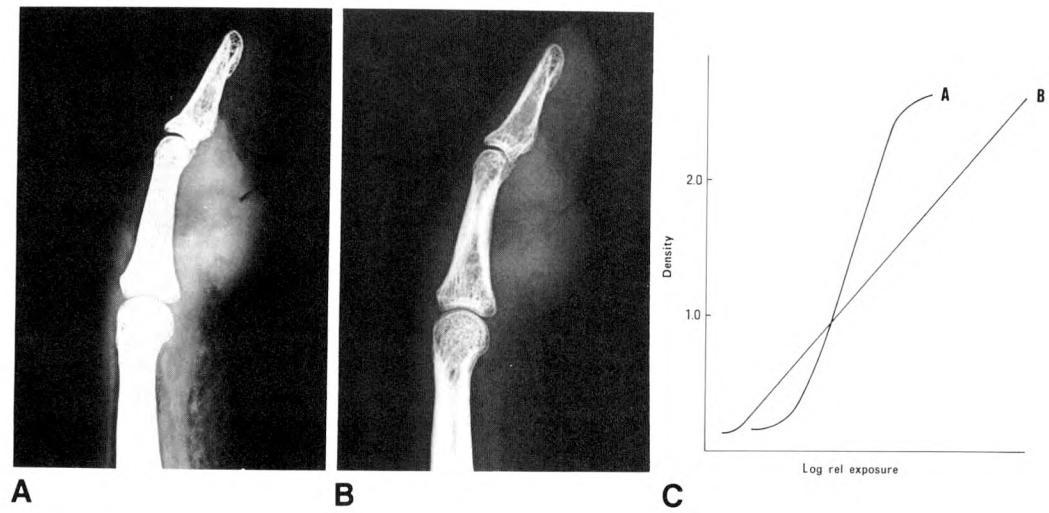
Effect of contrast enhancement that uses intensity transformation. Computed radiographic magnification image ($\times 3$) of epiphyseal sarcoma is displayed with different transformation curves for soft tissue (A) and bone (B) from same image data. The radiographic technical factors were 40 kVp, 10 mAs, and 90 cm focus-film distance with 0.1-mm focal spot size. Entrance skin exposure was 1.0 R (25.8 mC/kg).
